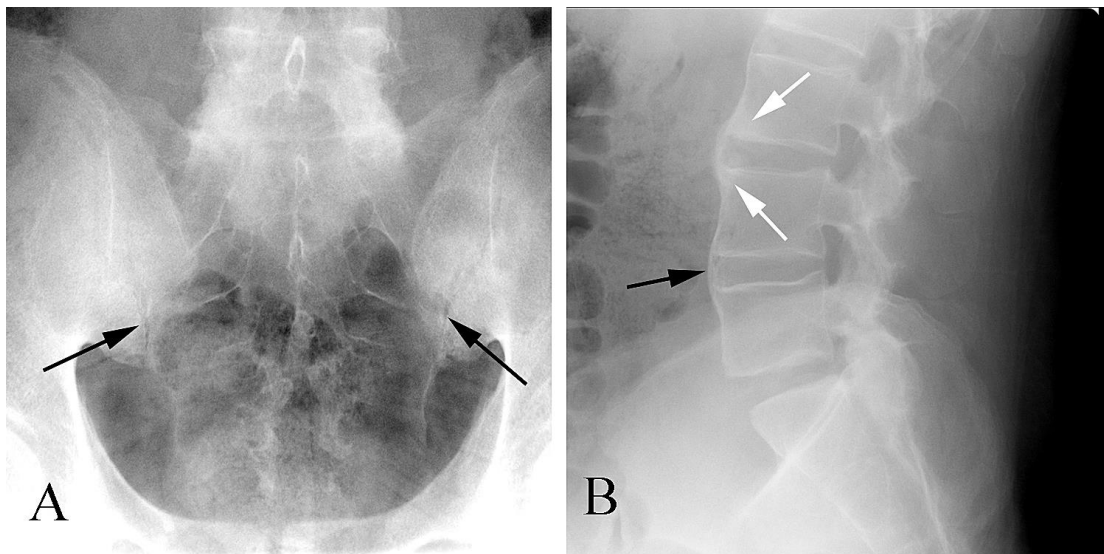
Ankylosing spondylitis in a 42 year old man with chronic back pain. A. AP plain film of the sacro-iliac joints shows erosions and loss of sharp definition along the inferior margins of the joints (arrows). B. Lateral plain film of the lower lumbar spine shows marginal syndesmophytes (black arrow) and "shiny corners" (white arrows) along the vertebral body margins.
